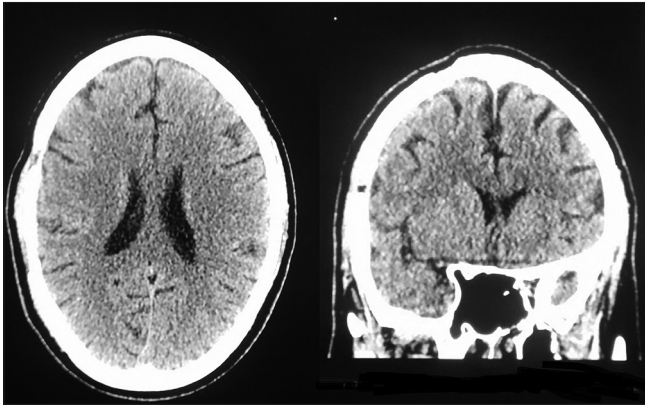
Postoperative computed tomography head showing craniotomy defect, no significant intracranial lesion; axial, coronal view
